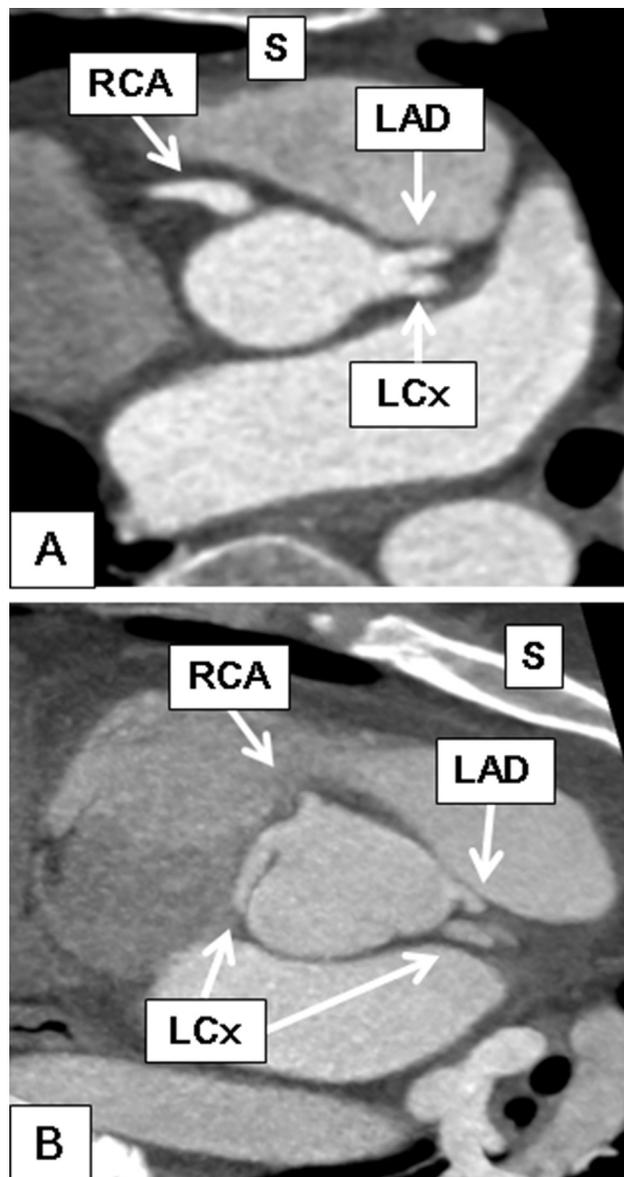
Computed tomography coronary angiography of two different coronary anomalies: A) Absent left main, B) LCx from opposite sinus. Figure annotations: S: Sternum; RCA: Right coronary artery; LAD: Left anterior descending coronary artery; LCx: Left circumflex coronary artery.
